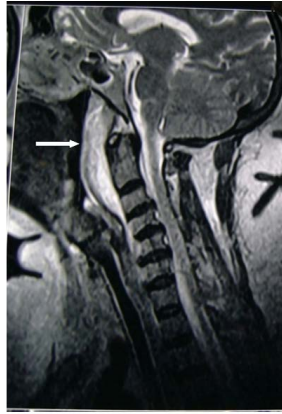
Retropharyngeal abscess in MRI neck (white arrow).
